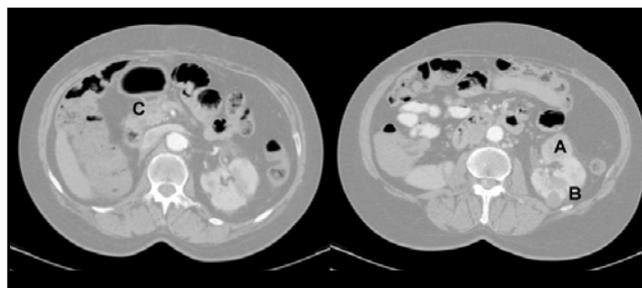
CT showed partial regression of pancreatic NET tumor (C) and stabilization of RCCs (A) and cysts (B) in left kidney.
